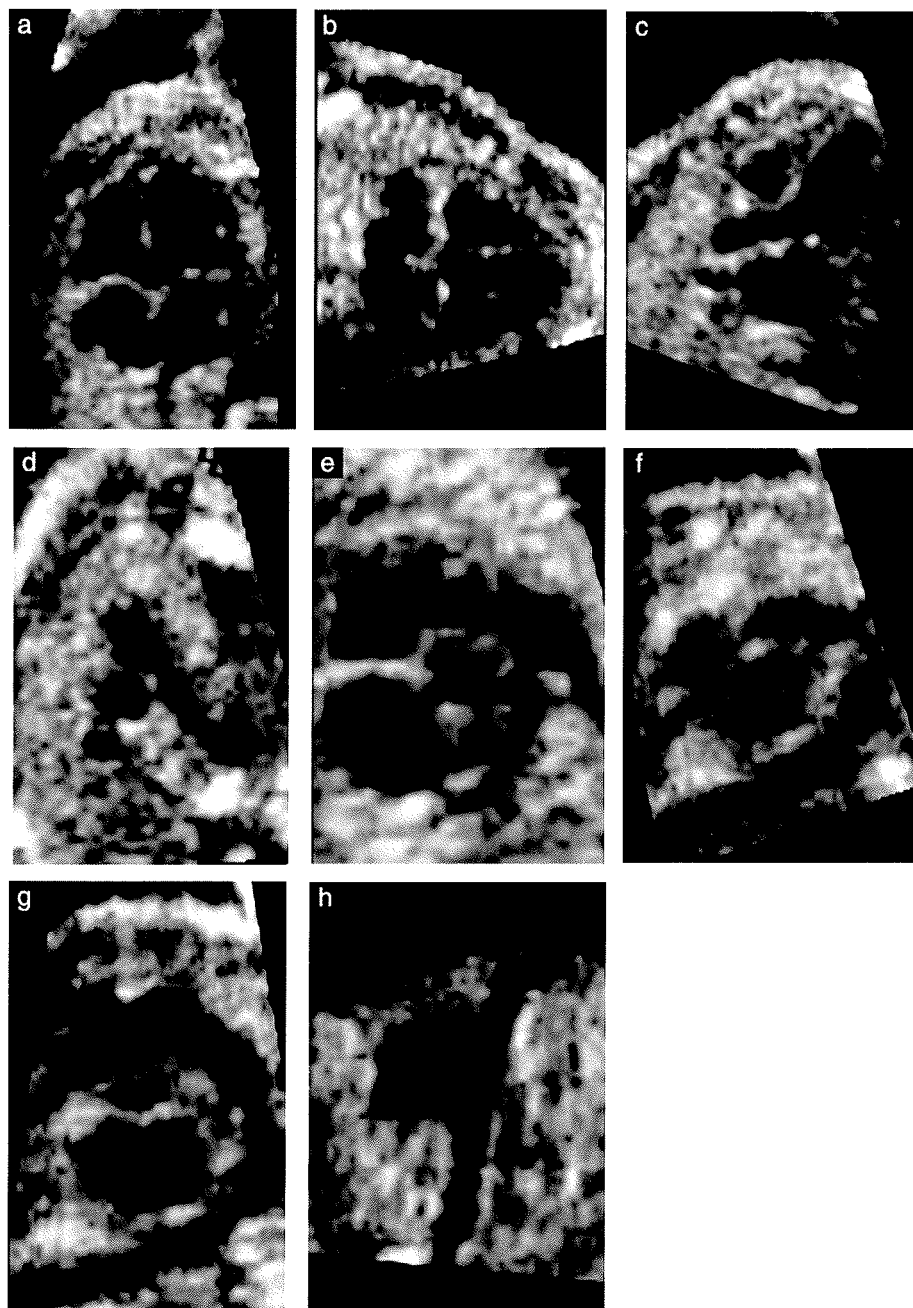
Volume projections of the heart of a fetus aged 24 weeks , all images retrospectively produced from one cine-loop of 3D data, derived by apical insonation. (a) Apical four-chamber view. (b) Subcostal four-chamber view. (c) Ascending aorta. (d) Three-vessel view. (e) Short-axis view. (f) Aortic arch. (g) Ductal arch. (h) Long-axis of inferior and superior vena cavae.
